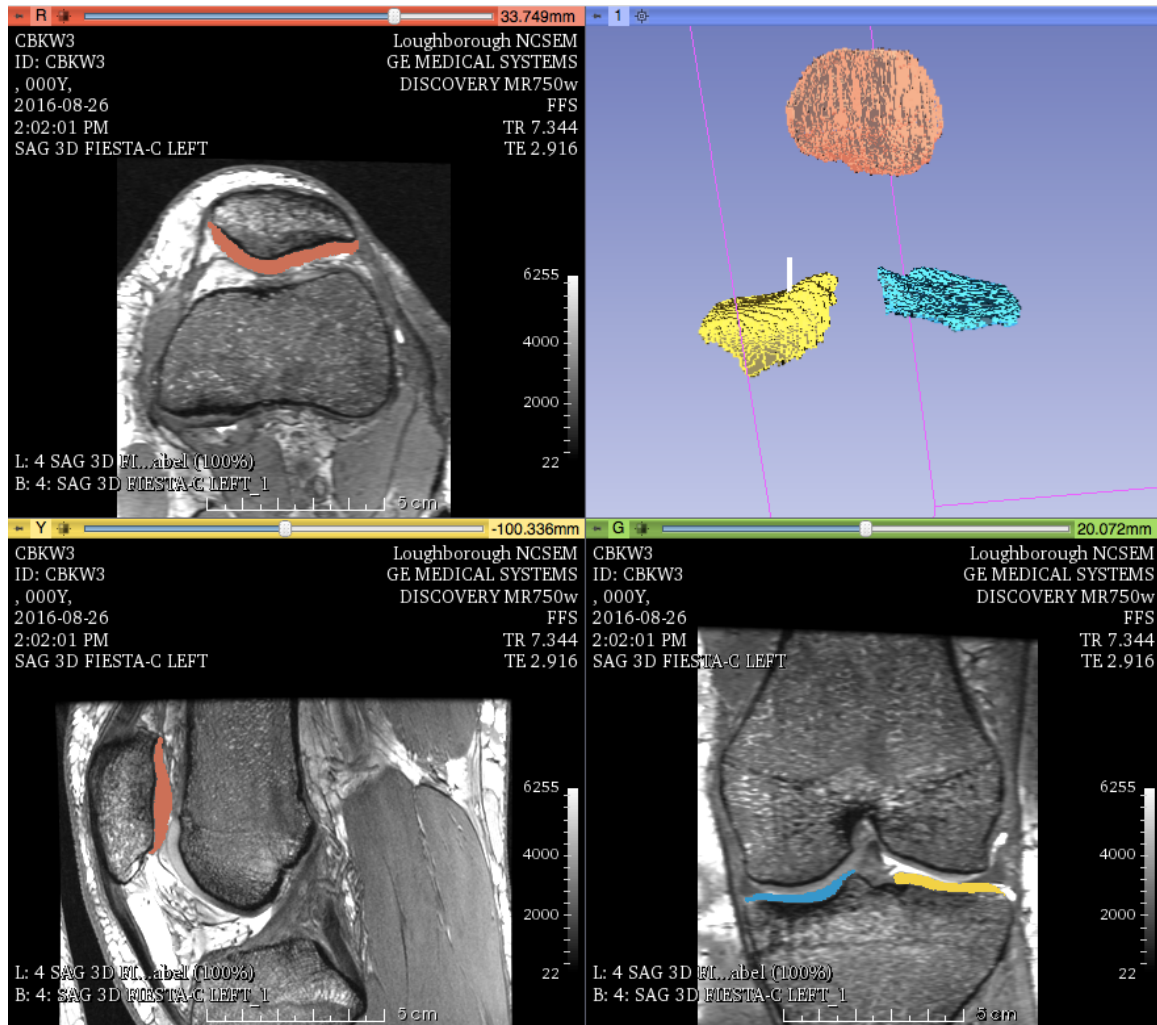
Three-plane view of a knee MRI as it appears in 3D Slicer, with patellar and tibial compartments segmented. The volume rendering of these compartments is shown in the top right frame.
